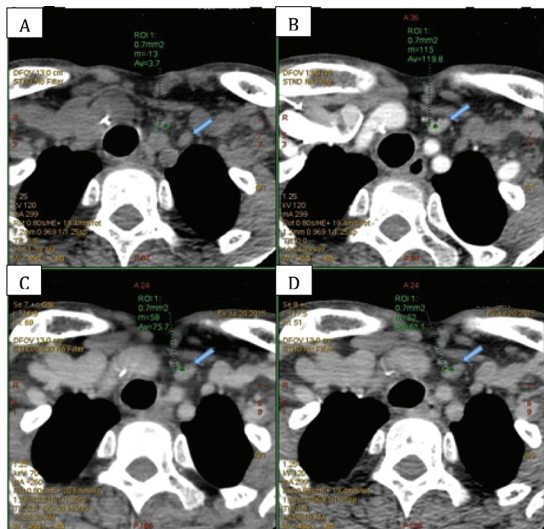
A 63-year-old female with PHPT. 4D-CT: (A) noncontrast; (B) post-contrast 30-second delay; (C) post-contrast 60-second delay; and (D) post-contrast 90-second delay, revealed surgically-proven ectopic parathyroid hyperplasia, which showed peak arterial enhancement and contrast washout at left upper paratracheal region.
